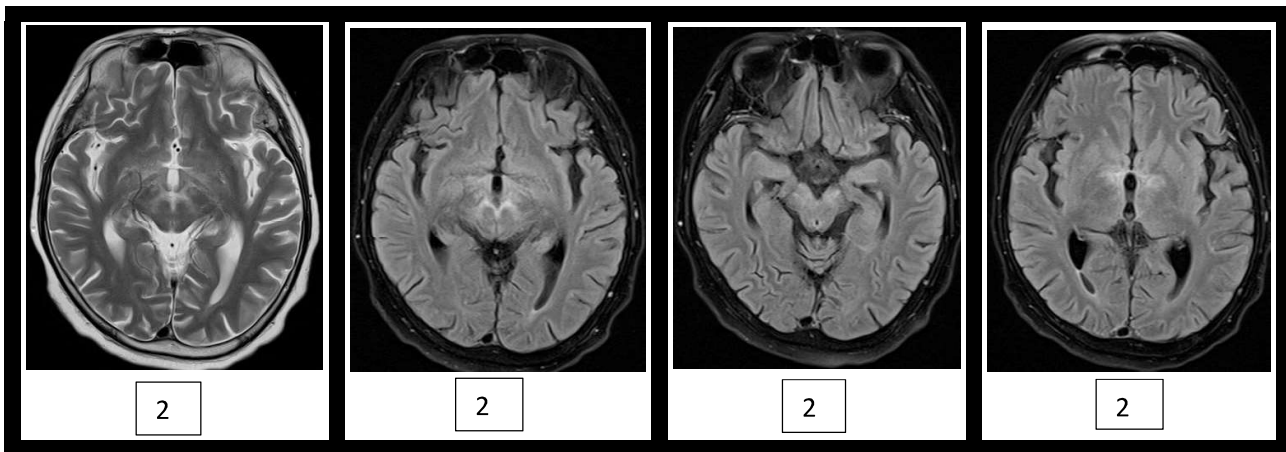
Repeat MRI; axial T2WI (2a) and axial FLAIR (2b, 2c and 2d) show residual hyperintensities of the midbrain, hypothalamus and periventricular region of third ventricle.
